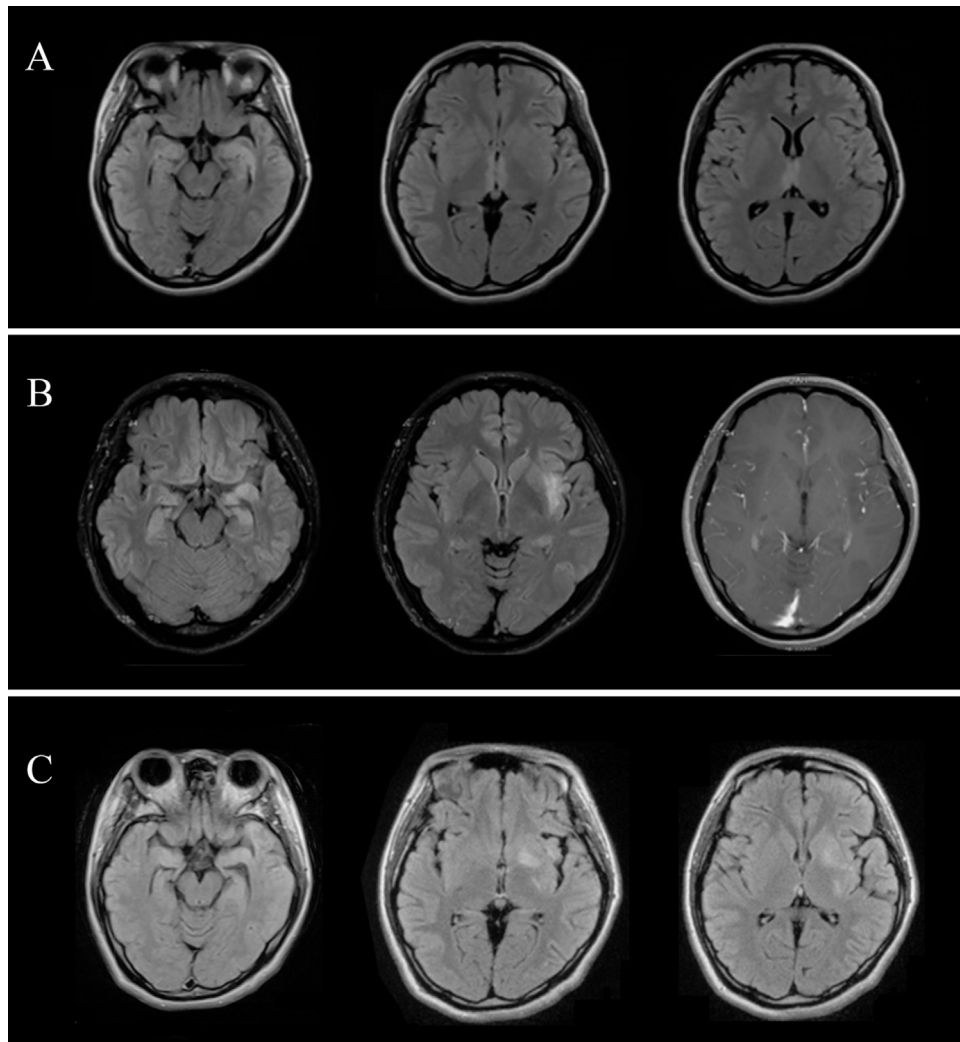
Brain magnetic resonance imaging of the patient. (A) 18 months before admission, T2-weighted fluid-attenuated inversion recovery (FLAIR) MRI shows abnormal hyperintense signals in bilateral medial temporal lobes and the brain parenchyma surrounding the third ventricle. (B) 10 months before admission, T2-weighted FLAIR MRI demonstrates lesions involving bilateral medial temporal lobes and left insular region without gadolinium enhancement. (C) During hospitalization, left basal ganglia lesions are depicted on T2-weighted FLAIR MRI, and the bilateral temporal lobes lesions are obviously relieved.
